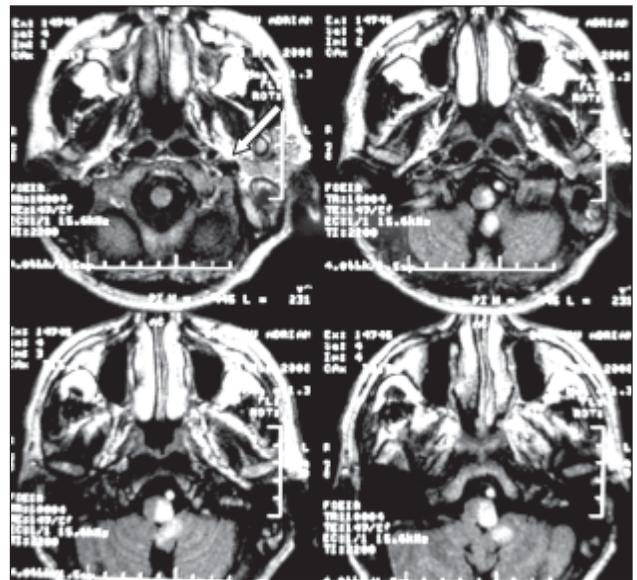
Cerebral MRI - T1 weighted image – a double lumen at the level of the right vertebral artery
